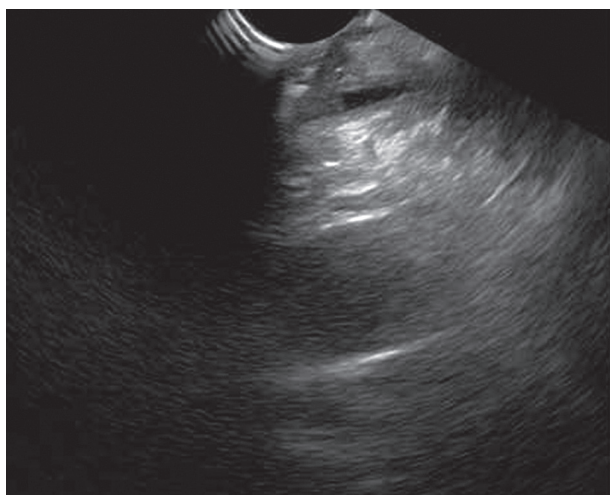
Endoscopic ultrasound upon admission. It suggested stenosis in the lower part of the common bile duct and swelling of the pancreas
